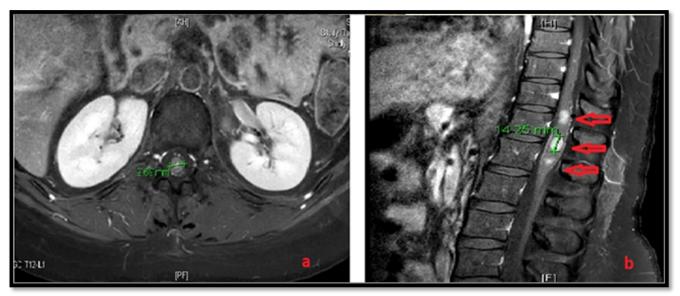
Medullary MRI in axial (a) and sagittal (b) coupes showing the presence of three nodular intramedullary lesions (arrows) in hyper intense STIR, the most voluminous one measuring about 13 x 8 x 7 mm.
